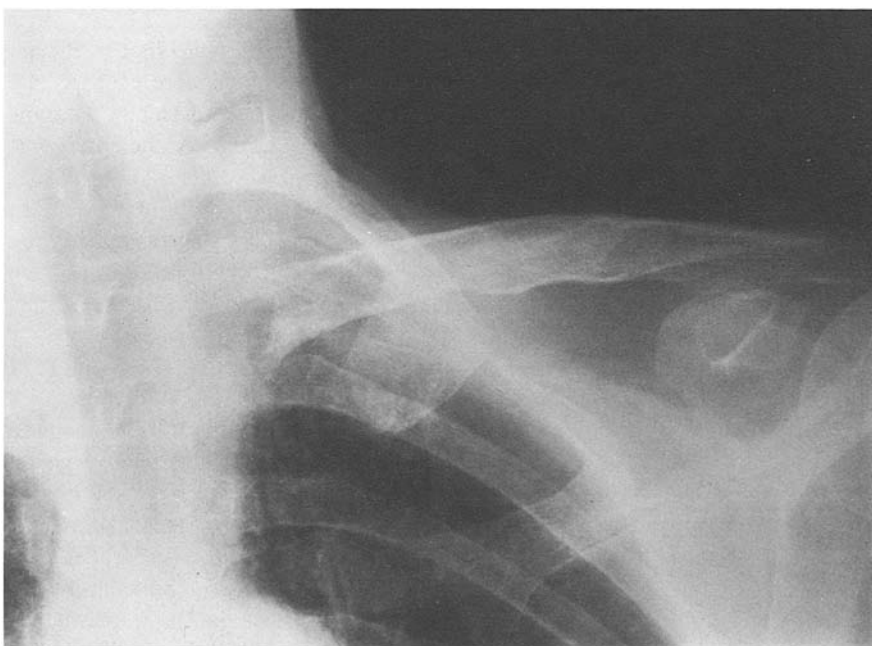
X-ray of same clavicle as in Figure 5, 11 months after starting chemotherapy. Lesion had not progressed when patient died of disseminated disease 39 months later
